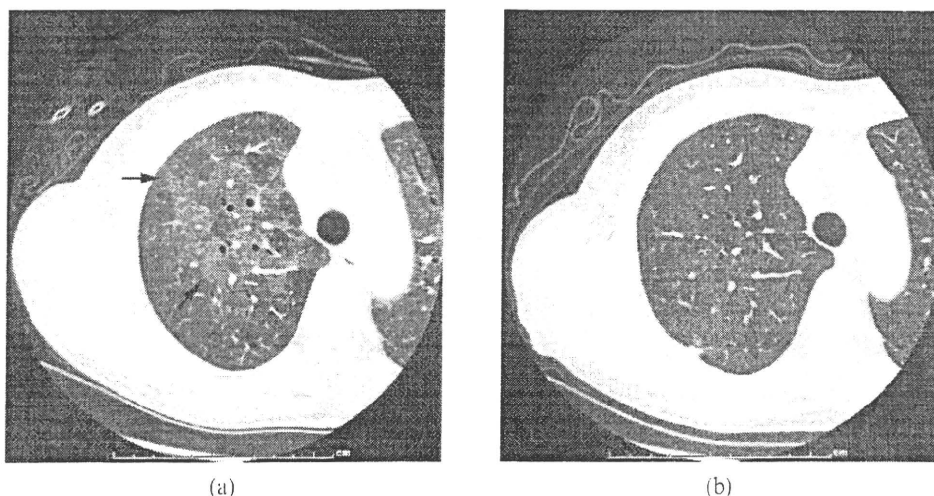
Images in a 69-year-old woman. (a) Transverse CT scan (1 mm section thickness) obtained at the level of right upper lobe shows ground-grass appearance (arrows; KL-6, 2940 U ml⁻¹). (b) Transverse CT scan (1 mm section thickness) obtained, after surgical biopsy 4 years later, shows disappearance of ground-grass opacity (KL-6, 313 U ml⁻¹).
